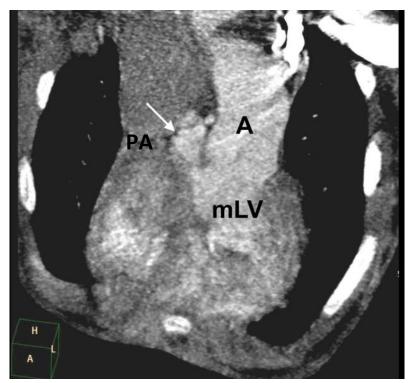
CT coronal image of 6 year old girl with double outlet left ventricle(same case as figure 23) has aortic root (A) and main pulmonary trunk (PA) arising in a parallel plane and both from morphological left ventricle (mLV). Which is designated as {_, _, L-MGA}.
